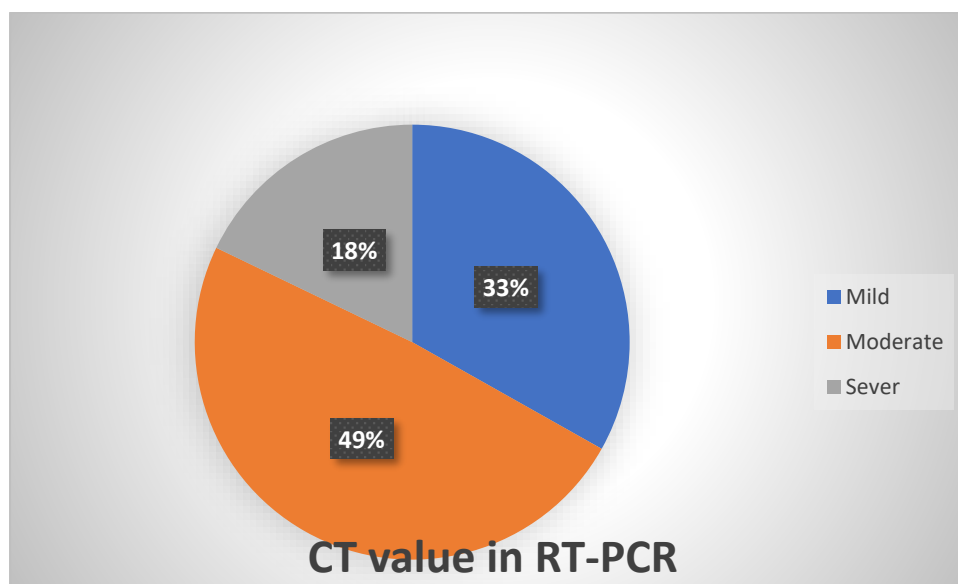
CT value in RT-PCR of patients
